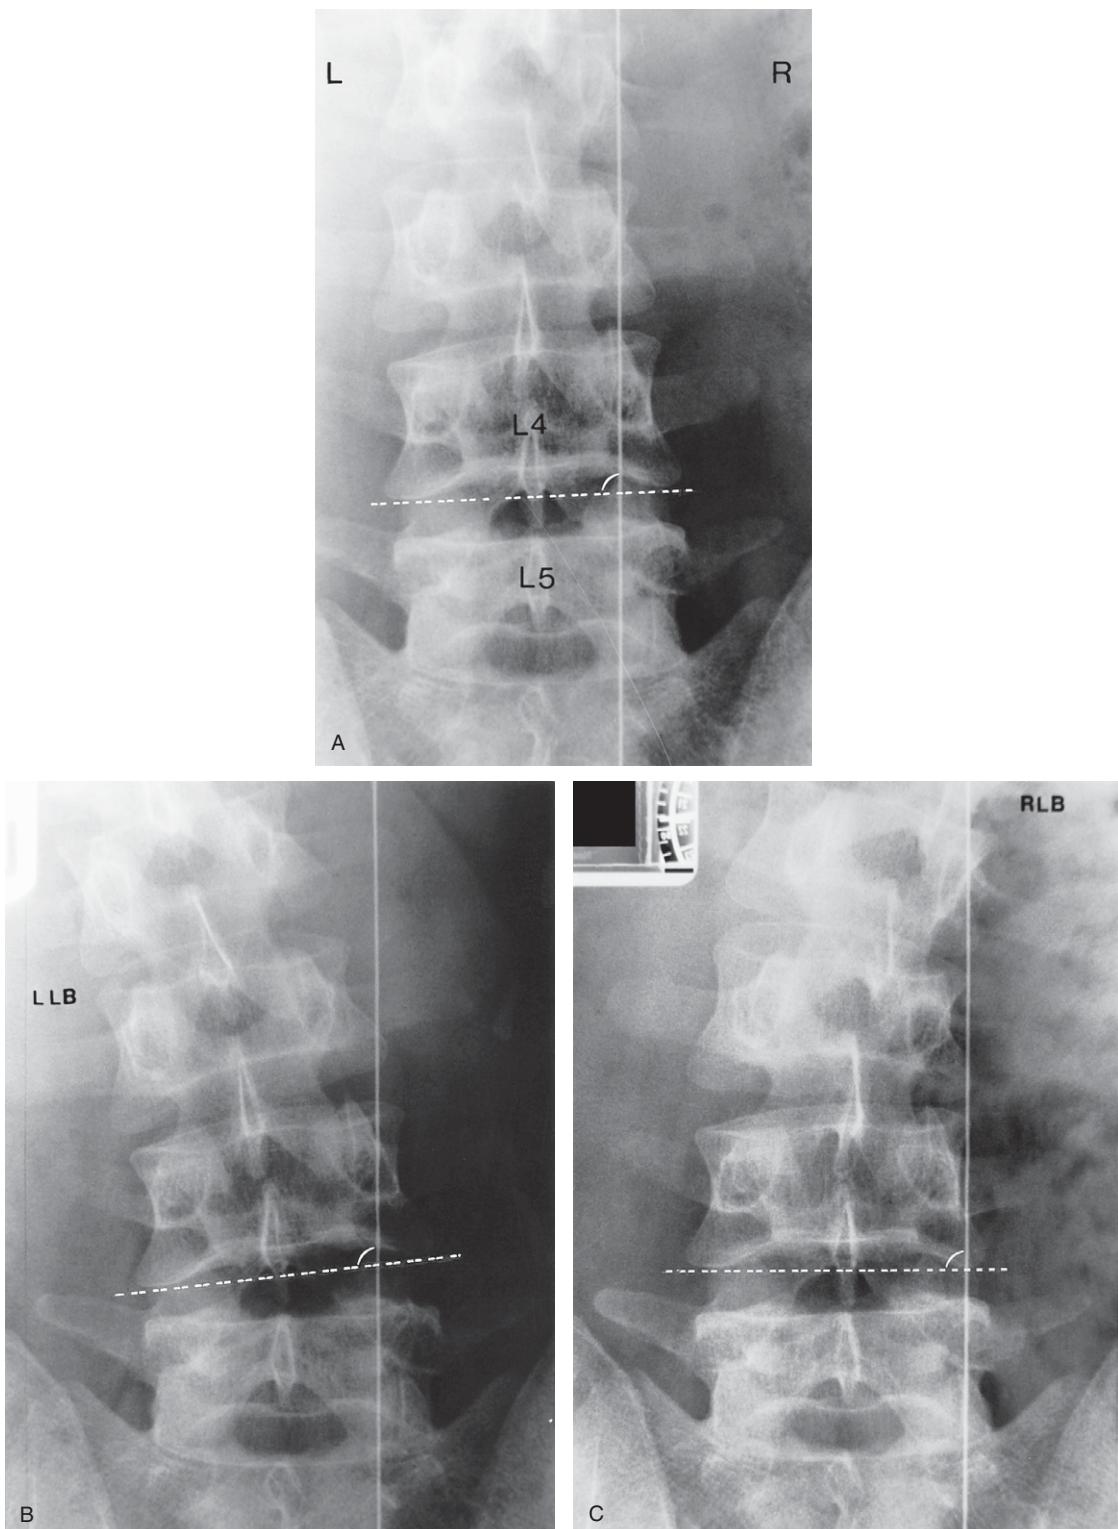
(A) Erect posture anteroposterior plain X-ray of the lumbosacral spine (L2–S1). Note the minor wedging of the L4–5 intervertebral disc which is slightly narrower on the left (L) as shown between the broken line across the inferior endplate of L4 and the superior endplate of L5. The angle between the broken line showing the inferior endplate of L4 and the vertical plumb line measures 93°. R = right side of patient. (B) Erect posture left lateral bending (LLB) plain X-ray of the lumbosacral spine showing normal wedging of the L4–5 intervertebral disc (which is narrower on the left) and the discs above, i.e. all disc spaces are narrower on the left side and wider on the right. The angle between the L4 inferior endplate line and the plumb line measures 97°. (C) Erect posture right lateral bending (RLB) plain X-ray of the lumbosacral spine showing the L4–5 intervertebral disc which refuses to wedge normally, i.e. to become narrower on the right and wider on the left; the discs above L4 do wedge normally, i.e. become narrower on the right side and wider on the left. The angle between the endplate line and the plumb line measured 91°, i.e. only approximately 2° less than in the neutral anteroposterior view shown in (A).
